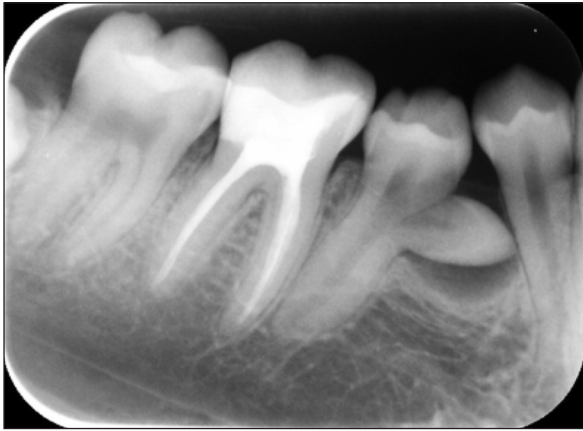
Periapical radiograph taken after 3 year follow-up.
